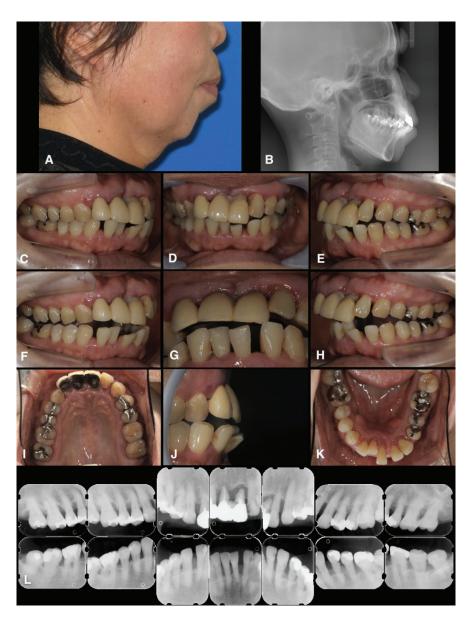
Pretreatment lateral facial profile (A), lateral cephalogram (B), intraoral photographs (C–K: C–E, G, J = intercuspal position; F = right lateral movement; H = left lateral movement), and periapical radiographs (L).
